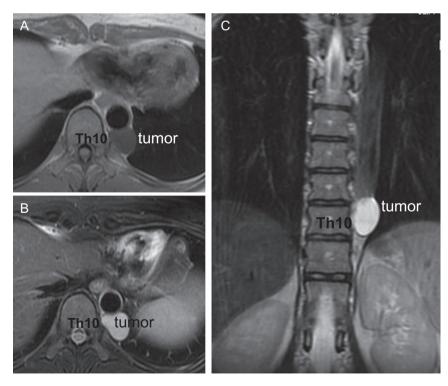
(A-C) Chest magnetic resonance imaging. A T2-weighted image showed a homogenous tumor with a high-intensity signal equal to water density
